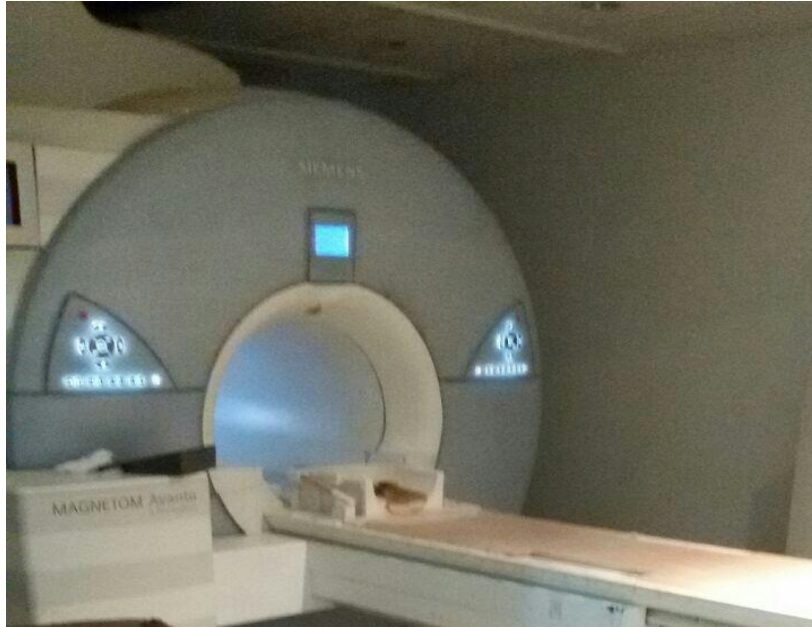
CLOSED SIEMENS MRI MACHINE 1.5 TESLA (GERMANY), (ALRIBAT UNIVERSITY HOSPITAL).
